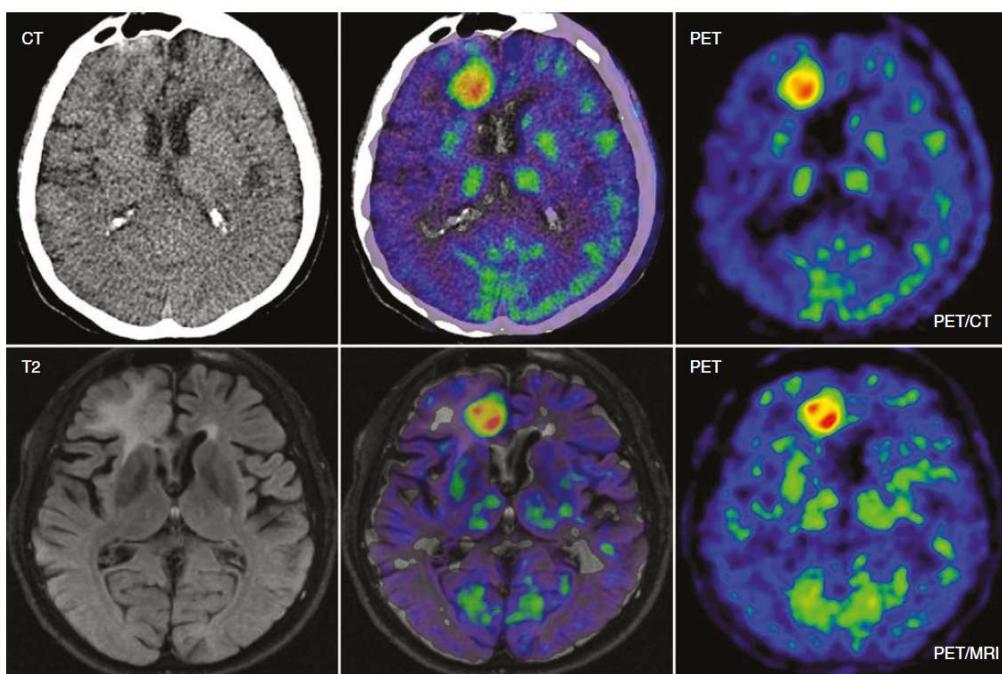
CT or MRI combined with PET gives very clear image of the tumour in brain and medical doctor can easily locate it in the context of general brain anatomy.
